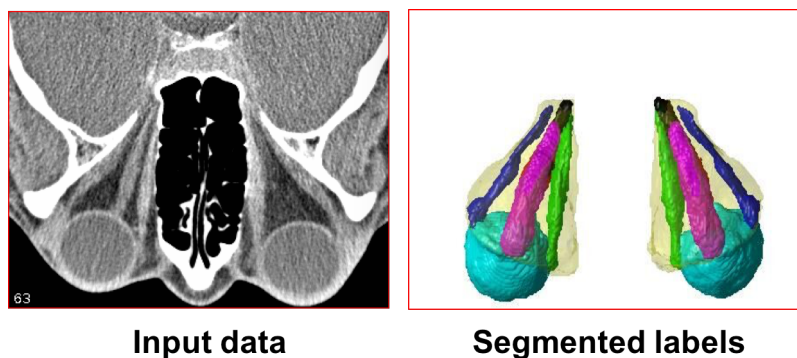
Result of segmentation. The image on the left side shows an input CT image, and the image on the right shows the segmented structures using multi-atlas segmentation. The structures segmented here are: the eye globe, the optic nerve, the superior, inferior, lateral, and medial extraocular muscles, and the orbital fat.
